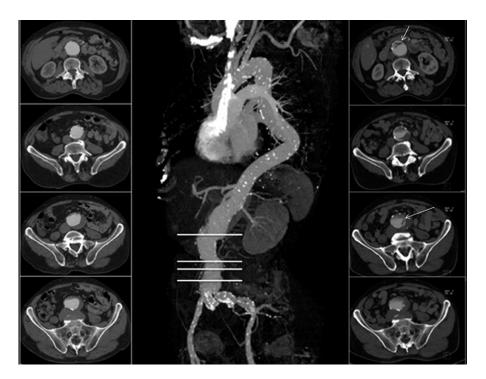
Computed tomography reconstruction of the entire aorta showing a juxtarenal aneurysm. On the sides are compared axial images 1 month before trauma (left) with the same scans after trauma (right). The *white lines* define the levels of images. Irregular and ulcerated/mobile thrombus (*white arrows*) is present along the whole length of the aneurysm at several levels.
